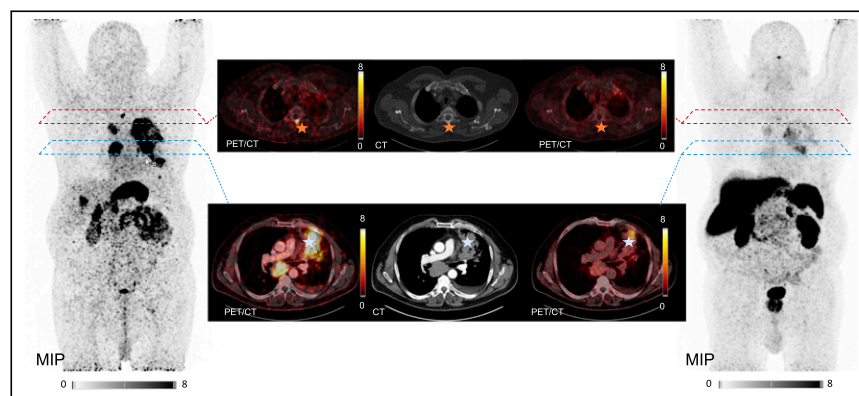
Maximum-intensity projections and transaxial slices of [⁶⁸Ga]Ga-DOTA-CCK-66 (left) and [⁶⁸Ga]Ga-DOTATOC (right) PET/CT. Red stars indicate bone metastasis in vertebral arch of second thoracic vertebra. Blue stars indicate pulmonary tumor mass in left upper lobe. Intensity scale bars are SUV. MIP = maximum-intensity projection.
